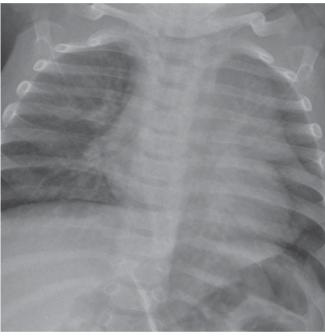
Varying appearances of the thymus. Anteroposterior radiograph (A) demonstrates a prominent right lobe of the thymus. Note the straight inferior border (*arrows*) and oblique lateral border giving the appearance of a sail. Close inspection of the lateral border (B) demonstrates an undulating wave-like edge (*curved black arrows*). Sometimes, the left lobe of the thymus may be prominent (C), and in such cases may be separated from the left heart border by a notch.
